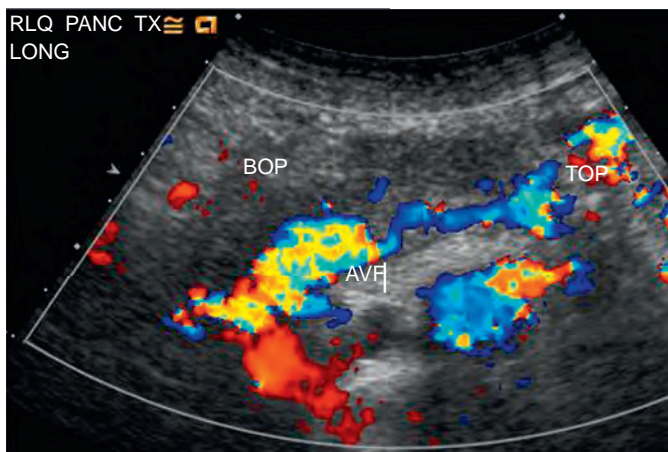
Iatrogenic arteriovenous fistula following biopsy in a 42-year-old woman after PTA. Longitudinal color Doppler sonogram shows a dilated tubular structure with turbulent flow closely associated with the transplant splenic vein and graft artery compatible with an arteriovenous fistula (AVF) within the proximal body of the pancreas (BOP). TOP, Tail of pancreas. (From Vandermeer F, Manning MA, Frazier A, et al: *Imaging of whole-organ pancreas transplants*. *RadioGraphics* 32:411–435, 2012.)
